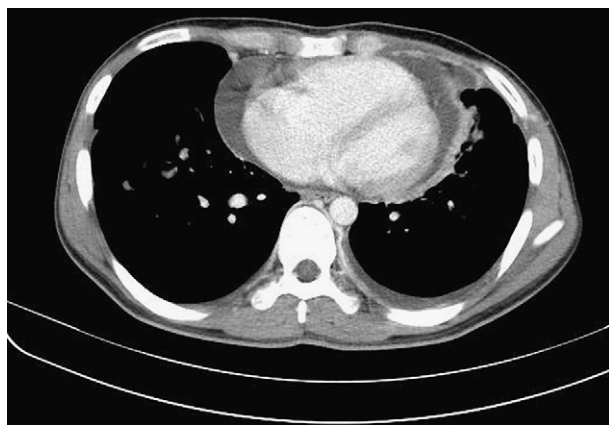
A computed tomography scan of chest with contrast enhancement shows pericardial effusion with pericardial thickening.
